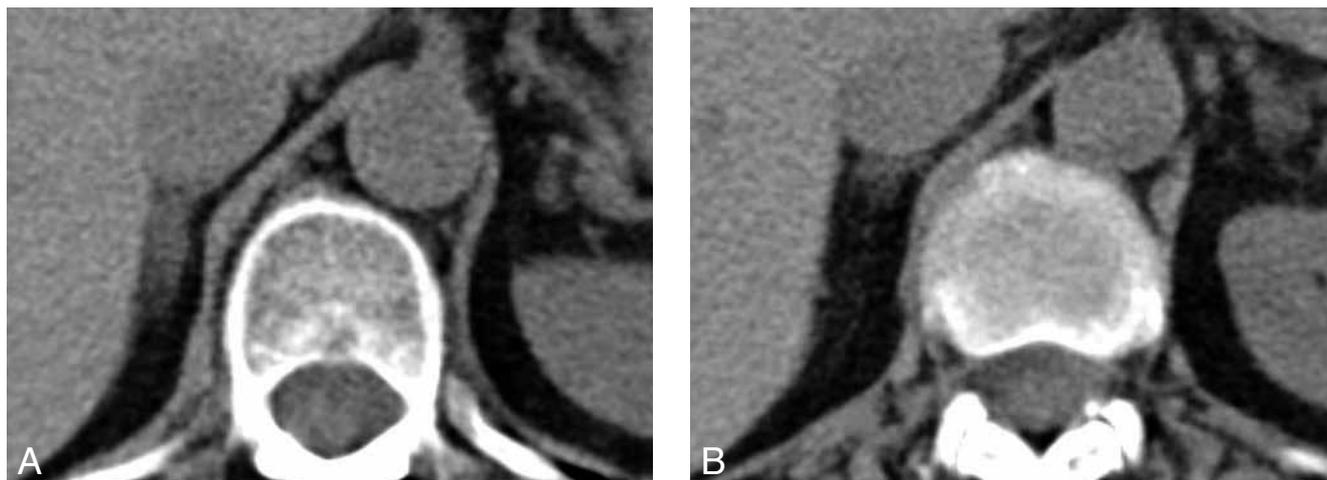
Follow up scan three months postoperative: unenhanced CT scan showing a normalized size and attenuation values of both adrenal glands (A = right, B = left).
